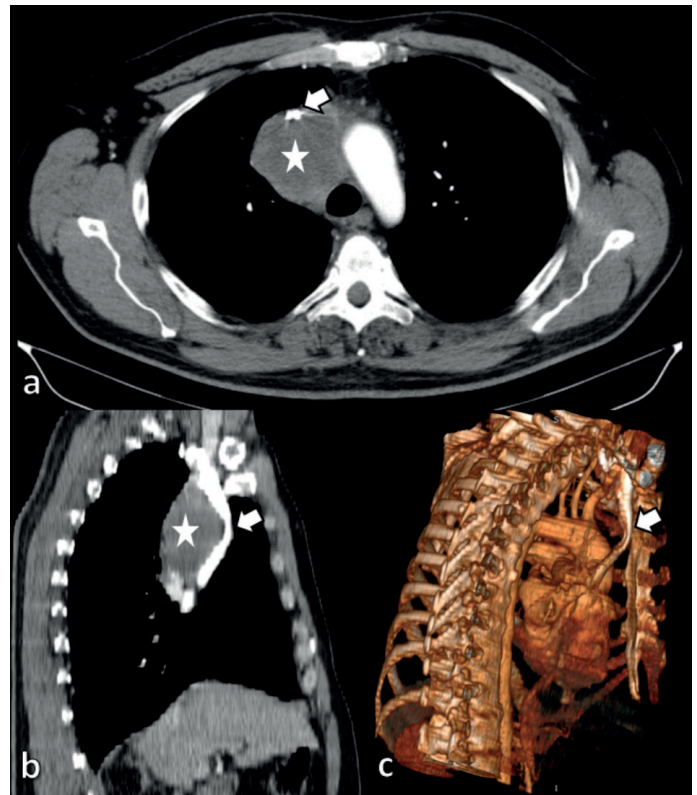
Axial and sagittal contrast enhanced thorax CT mediastinal window images (a, b) and 3D reformat image (c) shows mass lesion (white stars) and partial obstruction of superior vena cava (white arrows).
